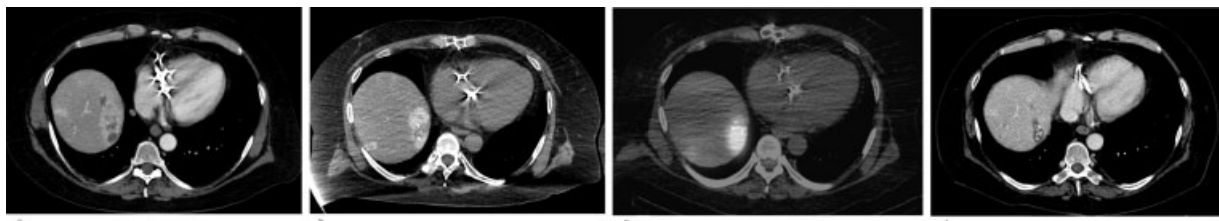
A 58-year-old man with metastatic small bowel neuroendocrine tumor was referred for radiation segmentectomy of an enlarging mass in segment 7 of the liver. Pre-transarterial radioembolization contrast-enhanced CT scan demonstrates an arterially enhancing heterogeneous mass with areas of necrosis in segment 7 (a). A CT arteriogram performed during workup confirmed superselective perfusion of this lesion by segment 7 right hepatic artery branch (b). $^{99\text{m}}\text{Tc}$ MAA SPECT/CT shows intense localized activity in the tumor, significantly higher than the surrounding normal liver (c). After delivering 153 Gy of ^{90}Y glass microspheres in segment 7 branch, a 7-month follow-up CT scan demonstrates complete response of the tumor by modified Response Evaluation Criteria in Solid Tumors (mRECIST; d).
